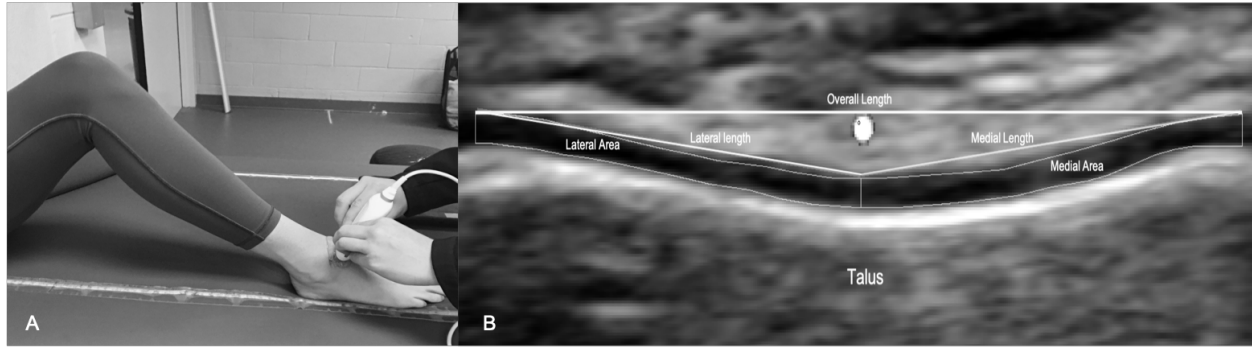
Ultrasonography image analysis. (A) positioning of participants and ultrasound transducer. (B) Cross-sectional area and length of each region of interest.
